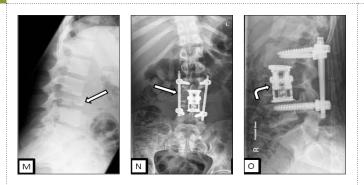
Figure M, a lateral lumbar spine radiograph, shows aggressive destruction of the L4 vertebral body, with cortical irregularity, loss of vertebral body height and anterior displacement of part of the vertebral body (white arrow). Figure N, an AP radiograph of the lumbar spine, and Figure O, a lateral radiograph, show post-operative appearances. There is evidence of a metallic cage device at the L4 level (curved white arrow), with spinal fixation at L3-L5 (straight white arrow)
